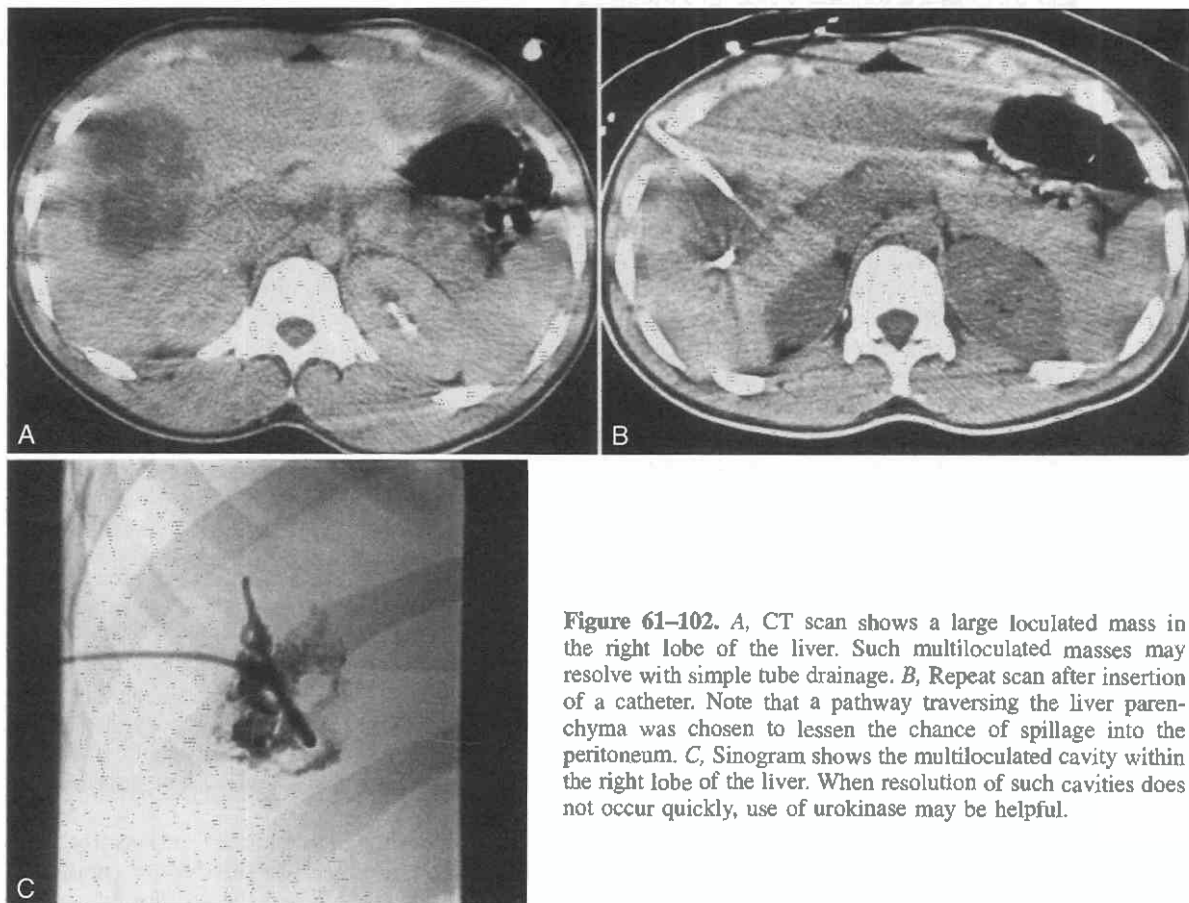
A, CT scan shows a large loculated mass in the right lobe of the liver. Such multiloculated masses may resolve with simple tube drainage. B, Repeat scan after insertion of a catheter. Note that a pathway traversing the liver parenchyma was chosen to lessen the chance of spillage into the peritoneum. C, Sinogram shows the multiloculated cavity within the right lobe of the liver. When resolution of such cavities does not occur quickly, use of urokinase may be helpful.
